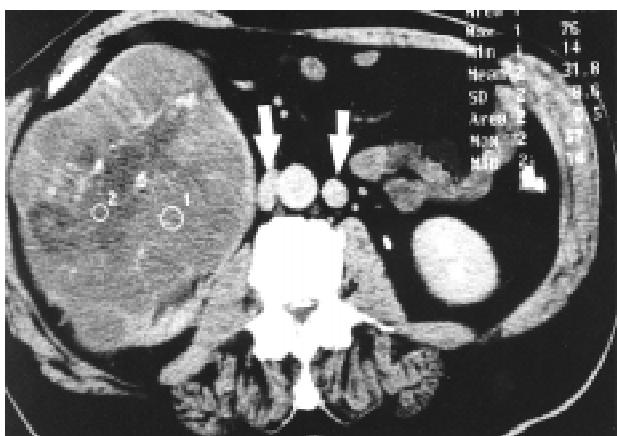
Computed tomography of the abdomen demonstrating a right renal neoplasm and an image of double inferior vena cava. The right and the left vena cava are located on each side of the aorta (arrows).
